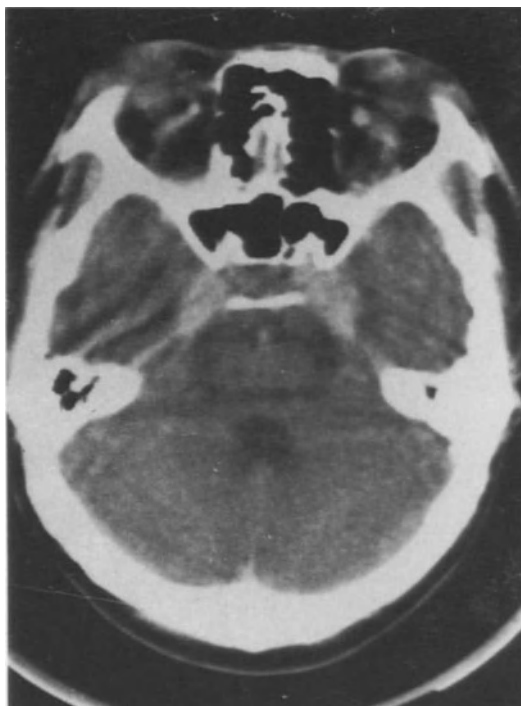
Axial CT scan with contrast medium showing abnormally high density in bilateral cavernous sinuses.
